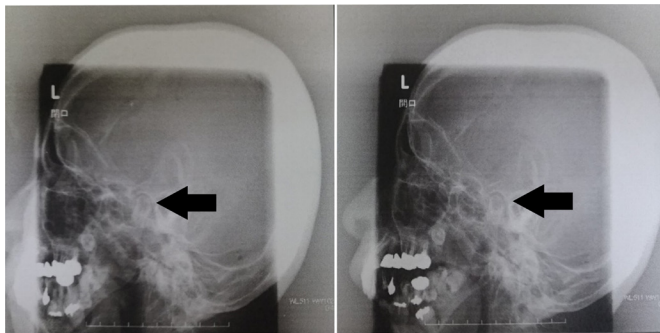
Schuller's radiographic method (left temporomandibular joint). As indicated by the arrows, the mandibular condyle has not moved forward even in the open position. The temporomandibular joint have not bone ankyloses and no fractures in the mandible. This figure is published with the patient's consent.
